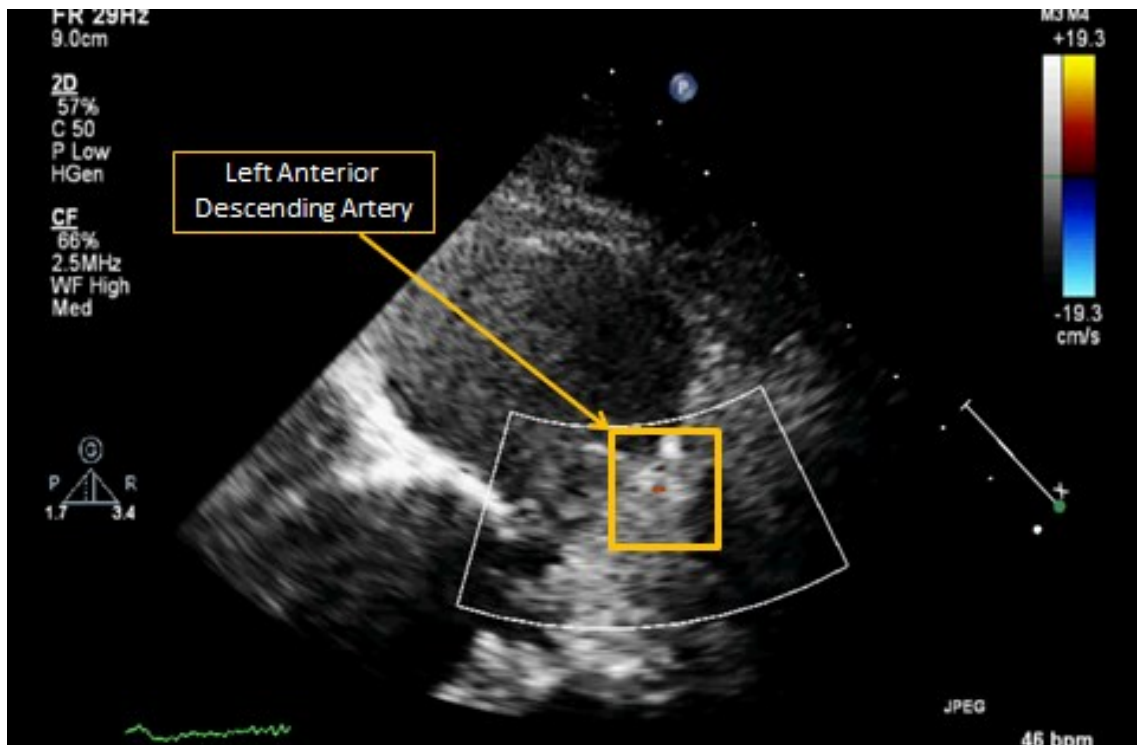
Proximal LAD visualised through a modified parasternal short axis view
